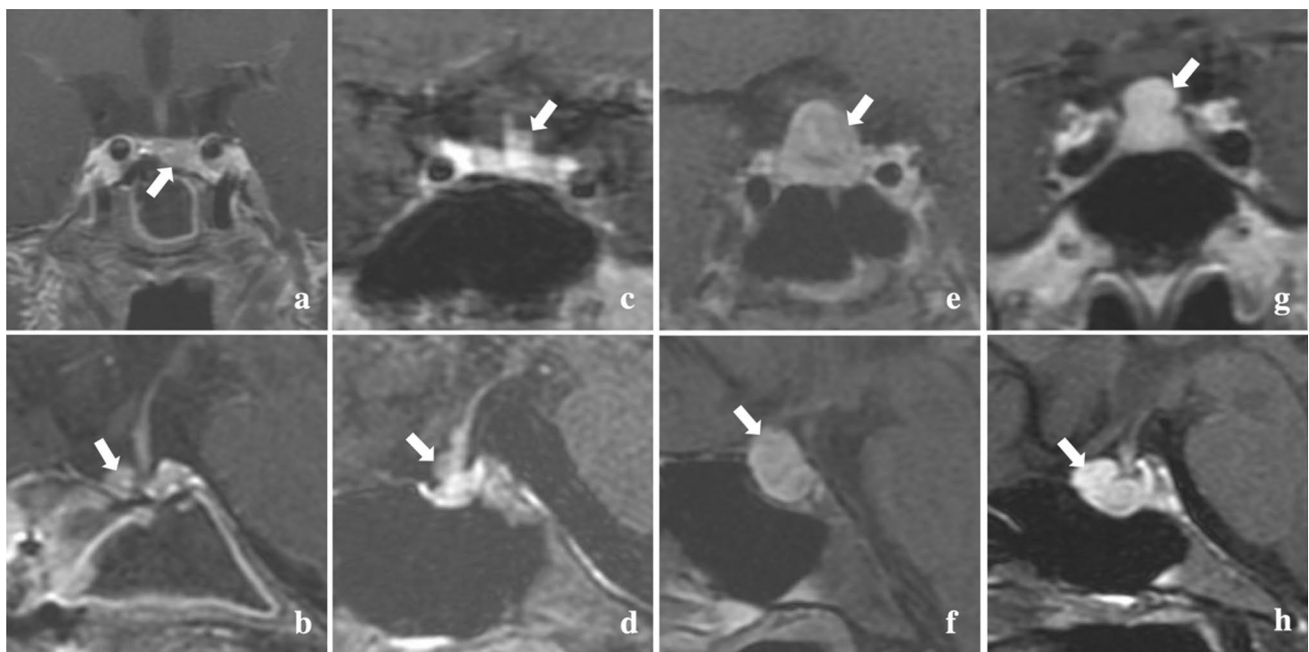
MRI presentations of Patients 10 (a, b), 11 (c, d), 12 (e, f) and 13 (g, h). White arrows show suspicious tumors
